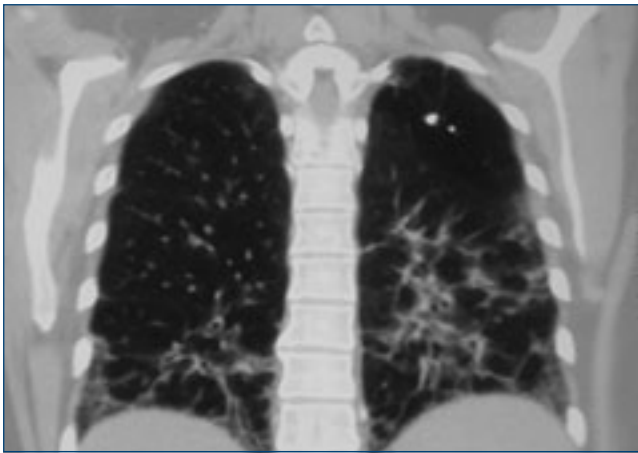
HRCT slides in lung parenchymal window confirmed the presence of interstitial syndrome with extensive areas of ground glass opacity, thickened interlobular septa and subpleural parenchymal bands in both lower lobes
